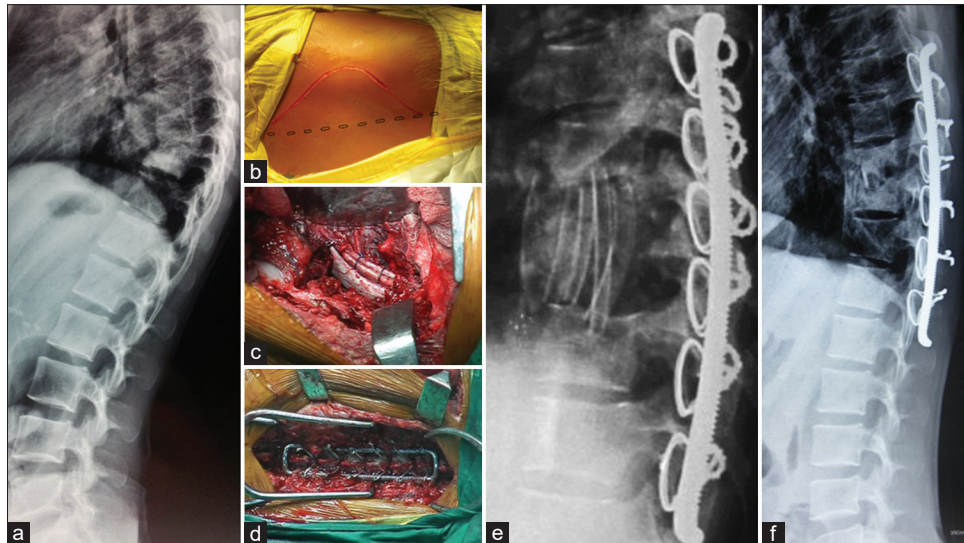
(a) Preoperative X-ray showing dorsal Kochæ With collapse. (b) Versatile approach technique. (c) Thorough decompression and rib graft insertion. (d) Hartshill rectangle and sublaminar wire. (e) Immediate postoperative X-ray. (f) X-ray at 3 months postoperative
